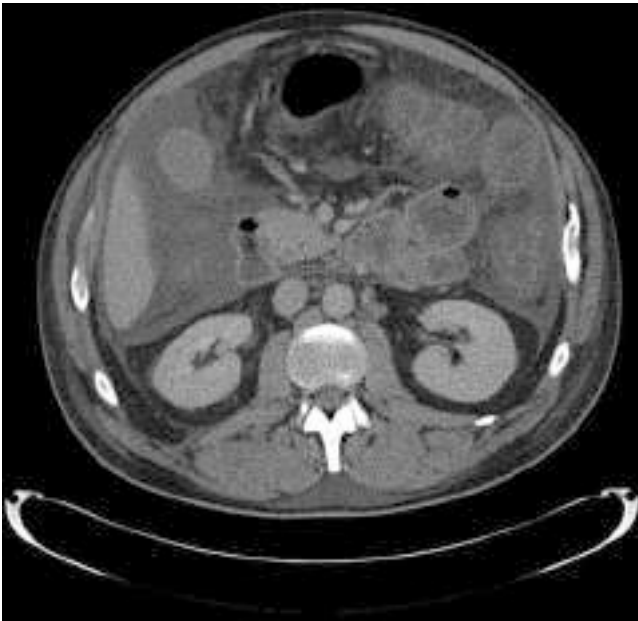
CT findings in a patient with severe, complicated CDI. Note the presence of ascites and the mural thickening of the left colon.
